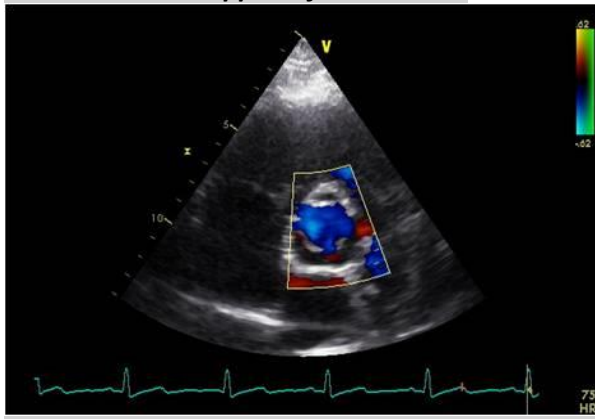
Color Doppler of aortic valve
